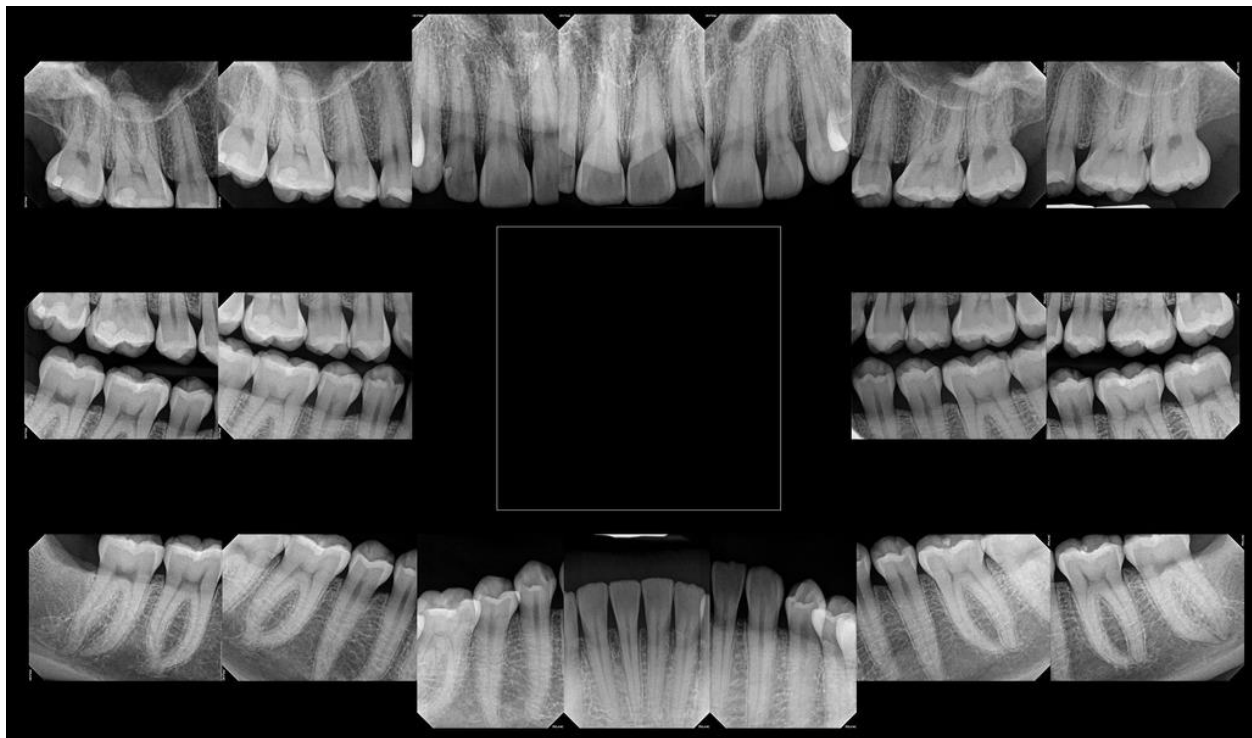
Intraoral radiographic survey
